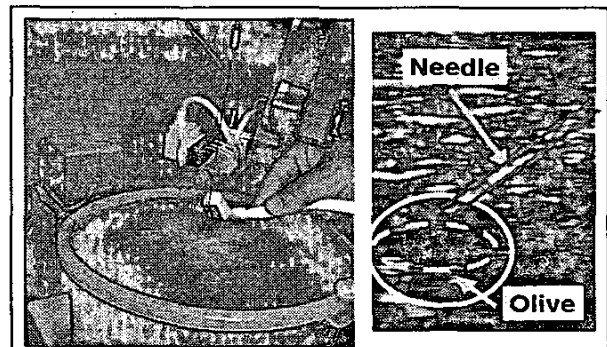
Ultrasound is used to assess needle placement with respect to the olive target embedded in calf liver
